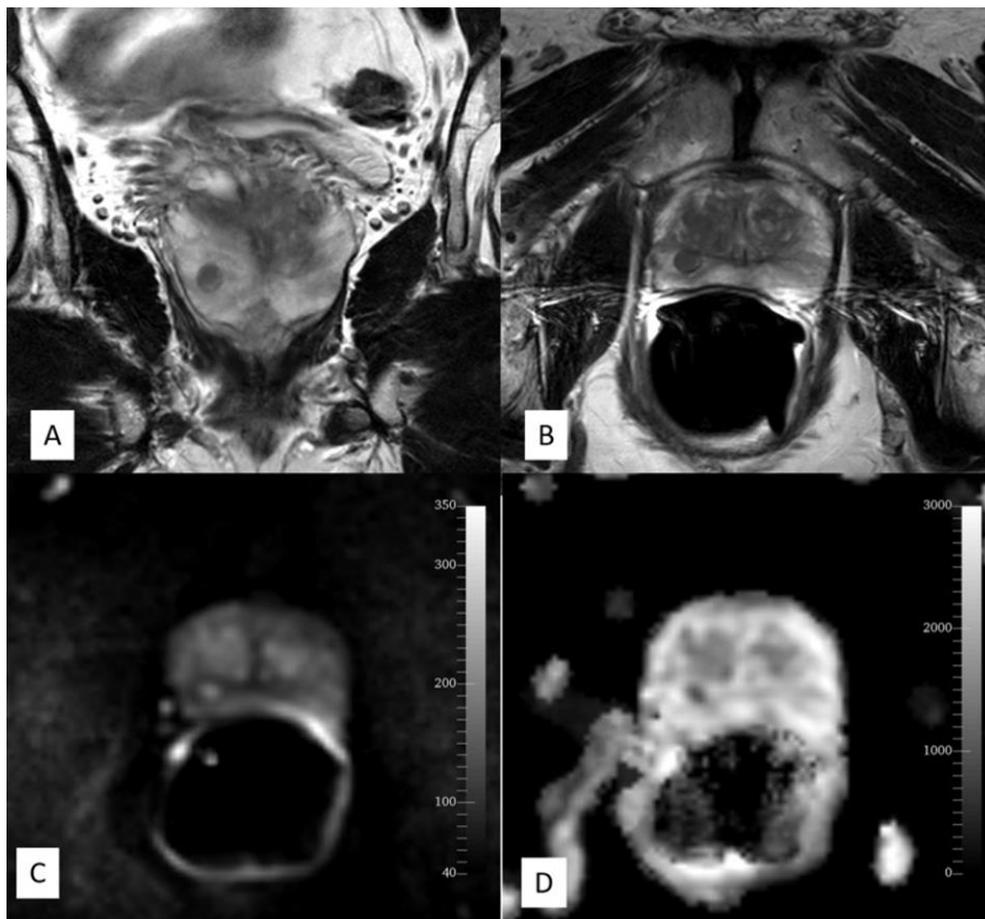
Magnetic Resonance Image of Prostate, Imaging Reporting and Data System 3 Classification.
